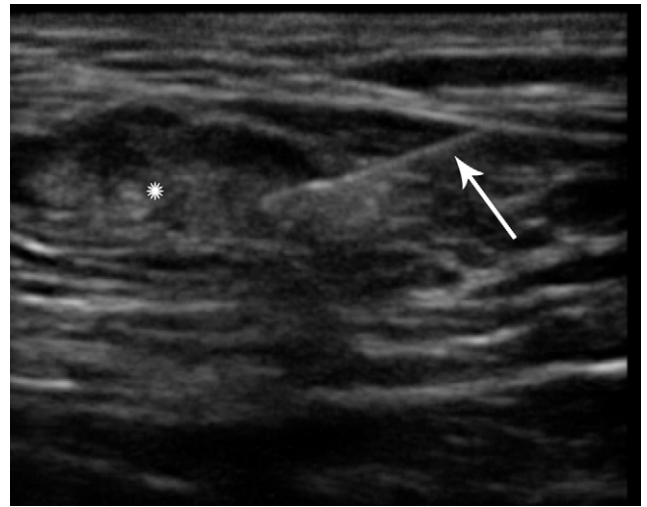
Ultrasound image shows access of the groin lymph node (star) with a needle (arrow).
